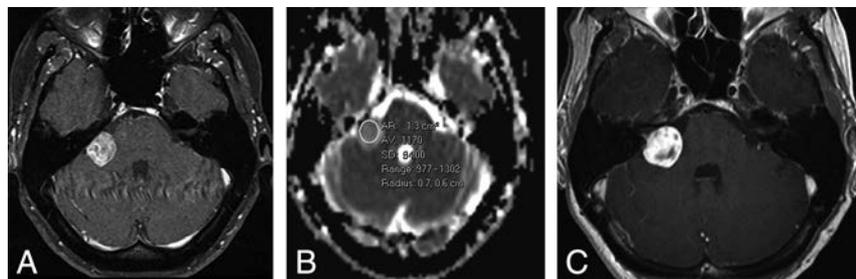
A, Right vestibular schwannoma at baseline on postcontrast axial T1-weighted scan. B, ADC calculation showing minimum value of $977 \times 10^{-6} \text{ mm}^2/\text{s}$. This would predict treatment failure. C, Four-year follow-up shows tumor growth on the postcontrast axial T1-weighted scan.
